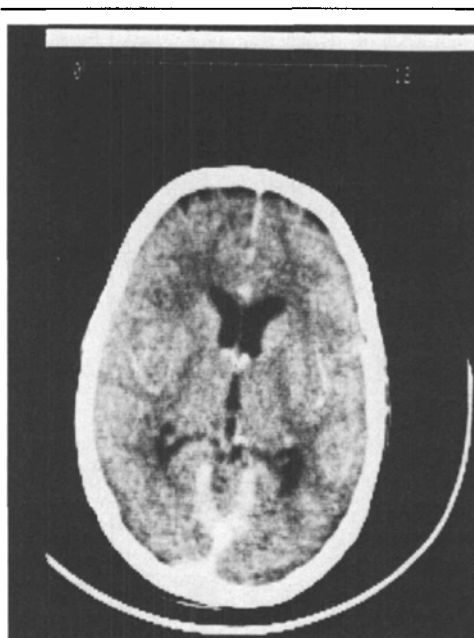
X-ray CT scan of normal brain at a comparable level to Figure 1.
